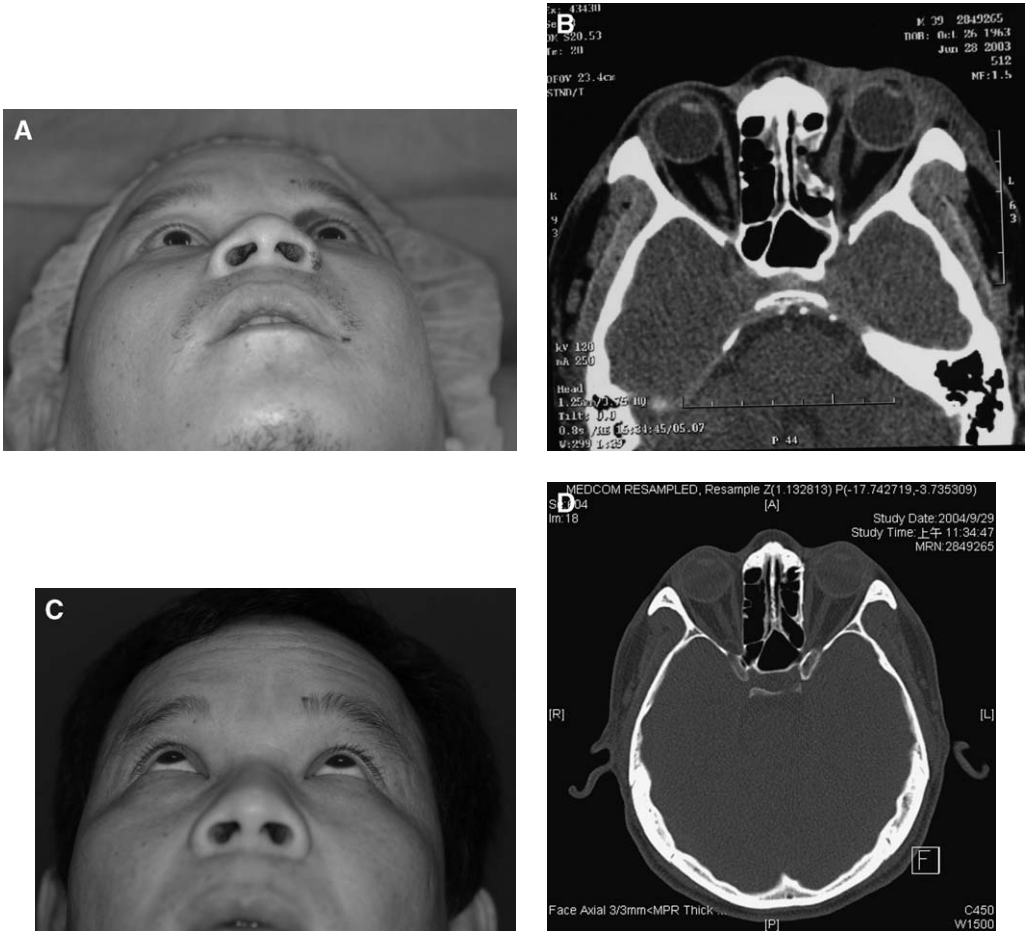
(A) 40-year-old patient with left orbital medial wall blow-out fracture. Preoperative submental view showing left upper eyelid ecchymosis and enophthalmos (1.5 mm). (B) Preoperative CT scan revealing a blowout fracture of the left orbital medial wall with soft tissue prolapse. (C) Postoperative submental view 5 months following correction of the orbital medial wall defect with symmetric projection of the globe. (D) Properly reconstructed medial wall with titanium mesh implant shown in postoperative CT scan.
